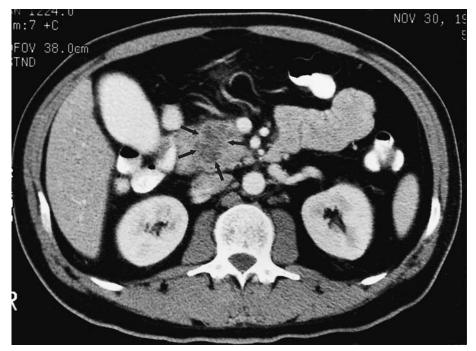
Abdominal CT can usually demonstrate pancreatic cancer if the mass is larger than 2 cm in diameter (arrows). (Courtesy of Henry I. Goldberg, MD.)
